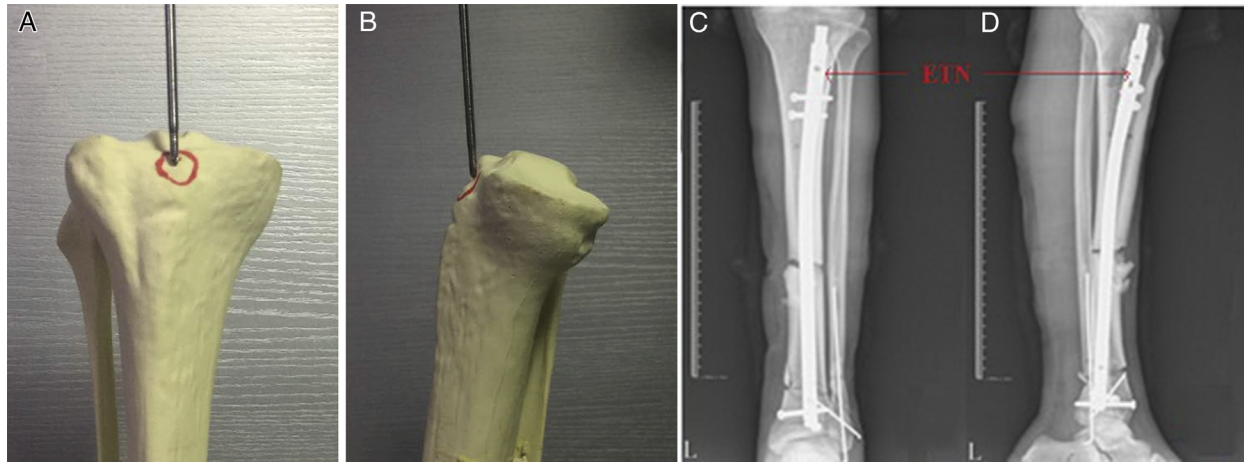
The entry point defines the optimal position of the Expert Tibial Nail (ETN) in the intramedullary canal. (A) On the anteroposterior view, the entry point (red circle) should be in line with the axis of the intramedullary canal and the lateral tubercle of the intercondylar eminence. (B) On the lateral view, the entry point (red circle) should be at the ventral edge of the tibial plateau. (C and D) Immediate postoperative anteroposterior and lateral radiographic films showing placement of the ETN.
